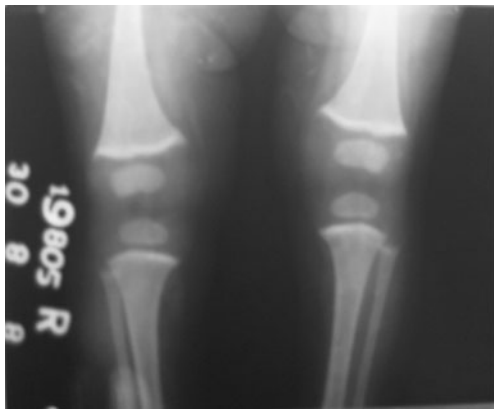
X-ray of the Knee showing lead line
